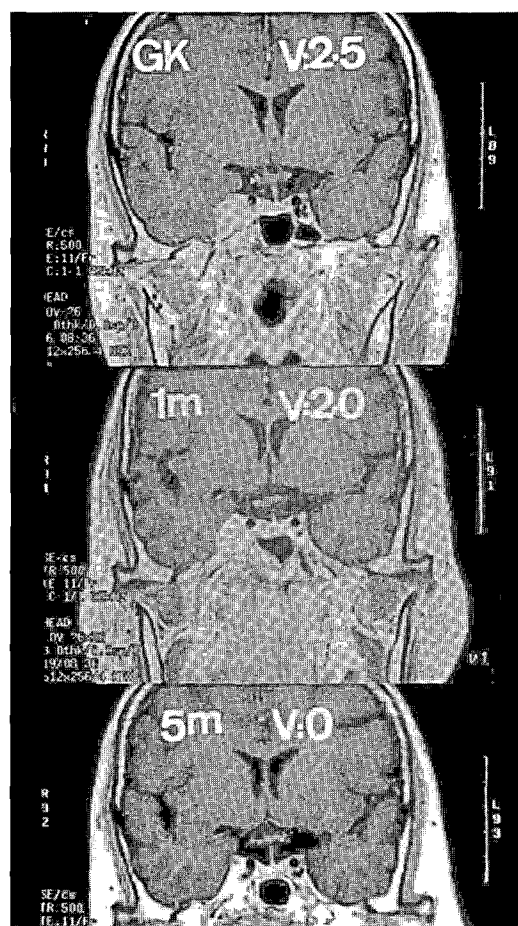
The MRI pictures of patient No. 2 (coronal view) before and after combined GK and fractionated RT treatment.
